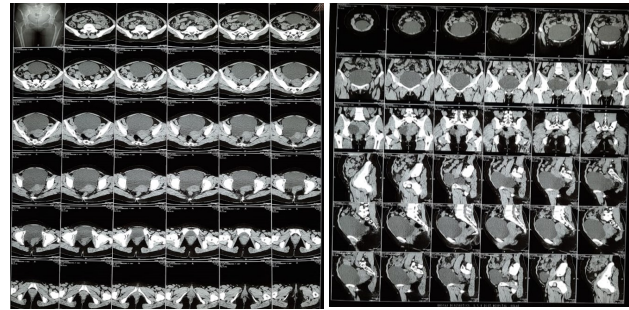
computed tomography of pelvis 2a. Axial view 2b. Sagittal view showing osteolytic lesion over right side pelvis.
